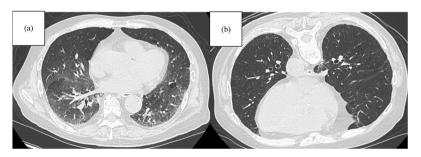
Axial CT scans showing the disappearance of ground-glass opacities due to gravity-dependent atelectasis and insufficient inspiration. (a) A chest CT scan performed with the patient in the supine position showed ground-glass opacities in the lower lobes, which disappeared (b) when the patient was placed in the prone position, proving that the ground-glass opacities were caused by gravity effects and insufficient inspiration.
